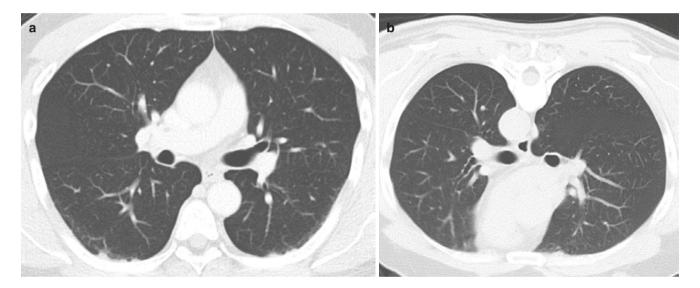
Utility of prone images in cancer imaging. (a) Axial CT image shows subpleural opacities in both lungs posteriorly. (b) Prone image shows complete clearing of the opacities in this patient (scan performed for staging of breast cancer)
